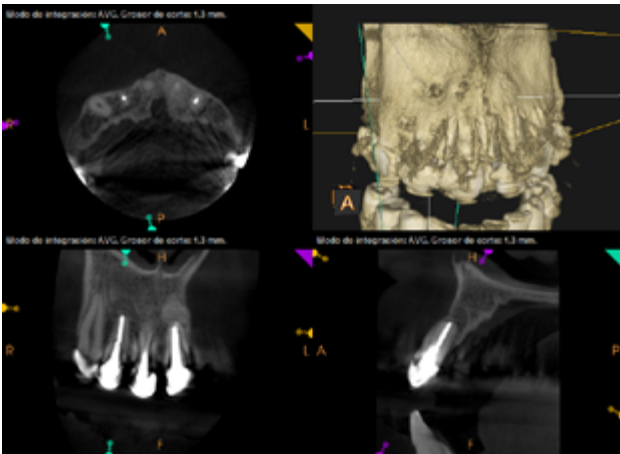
Control tomographic image at the level of 12, 18 months after periapical microsurgery in which the resolution of the pre-existing periapical radiolucent lesion can be seen.
